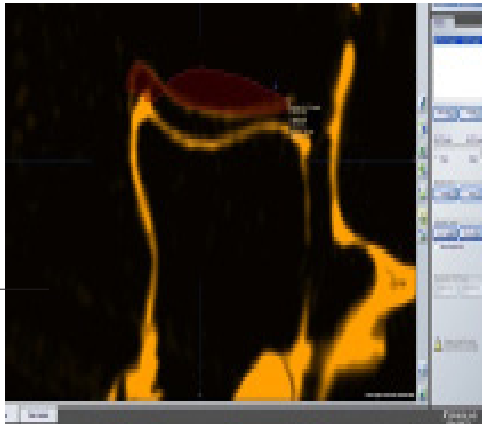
Sagittal view of fused CT scan images of realized (in yellow) and planned (in red) implant position at the anterior and posterior ledge position of the orbital floor
